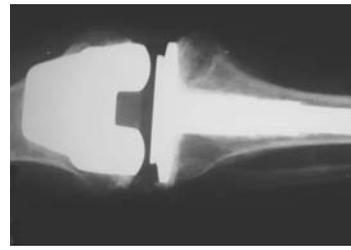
Total prosthesis with 70-millimeter intramedullary tibial extension nail – radiograph in anteroposterior plane
